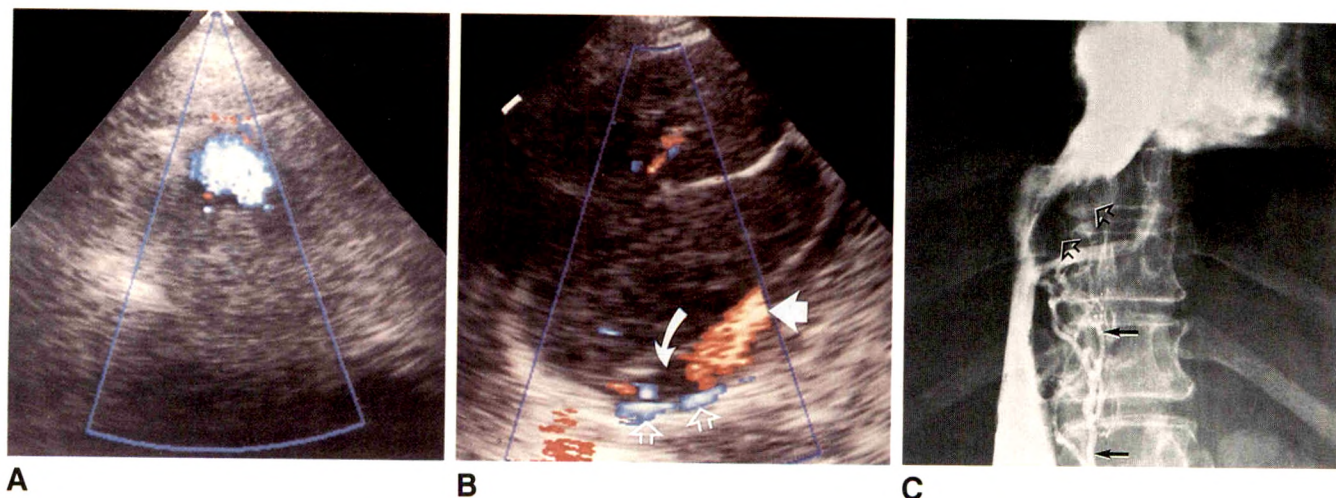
A, Transverse color Doppler image in right subcostal area shows a patent mesoatrial shunt.
